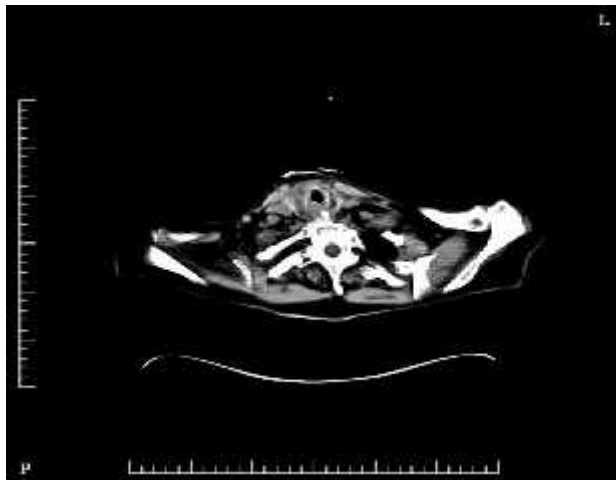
Axial computed tomography scan showing a right-sided, supraglottic, soft tissue mass. L= left; P = posterior
